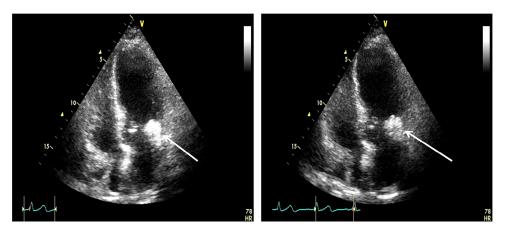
Transthoracic ultrasound, long-axis projections: hyperechoic cardiac mass (arrows) in a patient with poor acoustic window.
